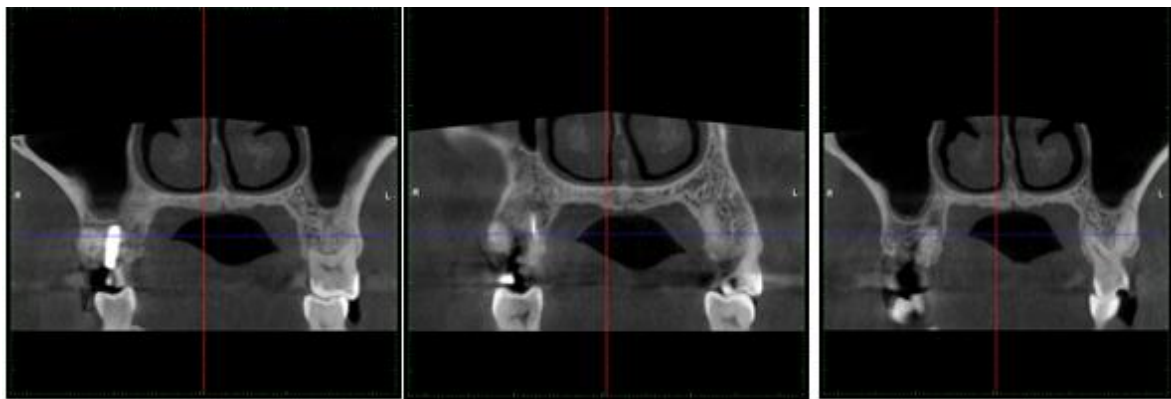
CBCT scan realized 24 hours after implantation
